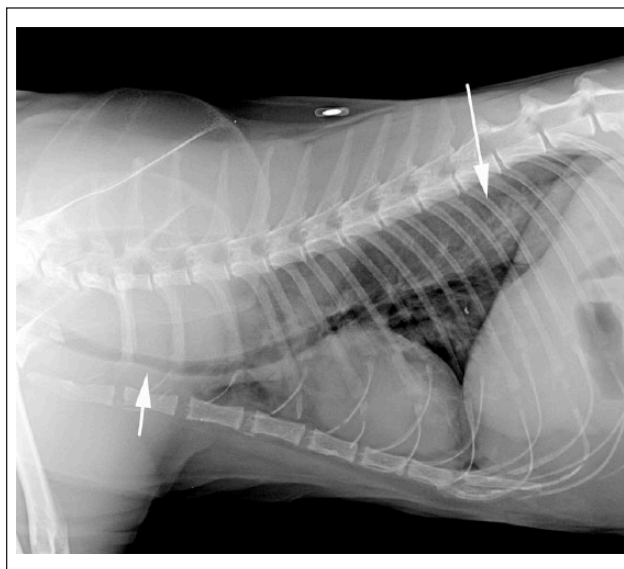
Right lateral radiograph. There is ventral deviation and narrowing of the trachea, most notably at the thoracic inlet (short arrow). Dorsal to the trachea and extending caudally to the diaphragm there is increased diameter and fluid opacity in the dorsal mediastinum consistent with the location of the oesophagus (long arrow)
